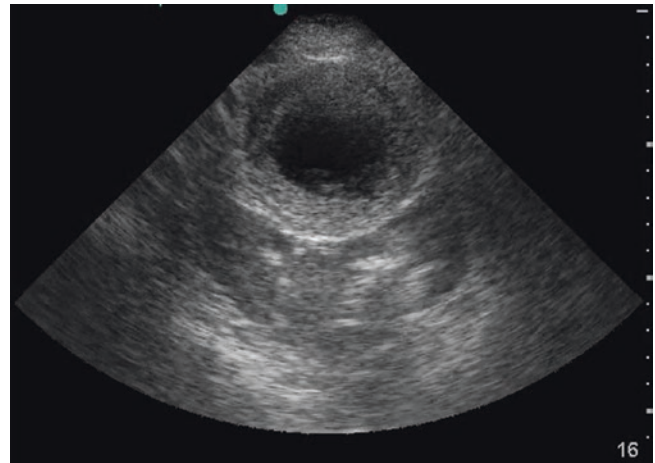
Point-of-care ultrasound demonstrating a thickened bladder wall in a patient with cystitis
